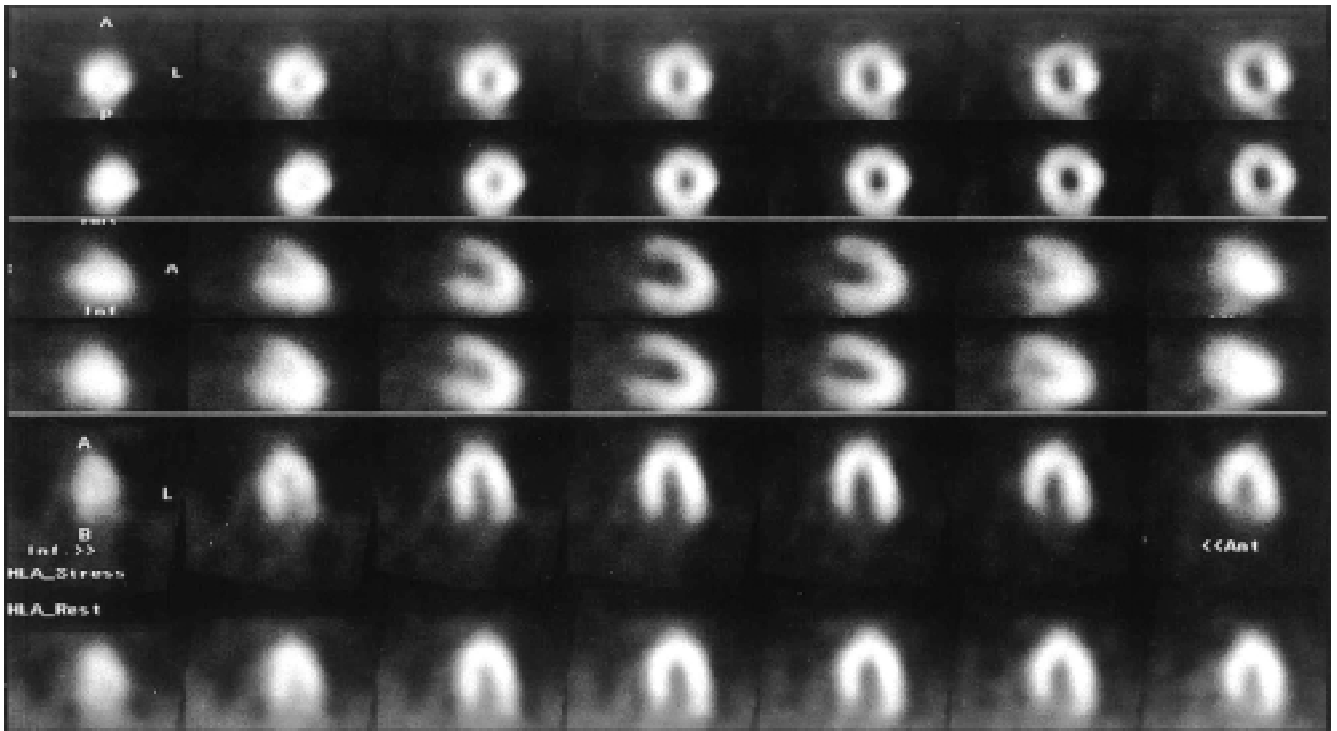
Thallium stress and rest SPECT images show reversible anterior and inferolateral perfusion defects compatible with ischemia in the territory of left anterior descending and left circumflex coronary arteries.
